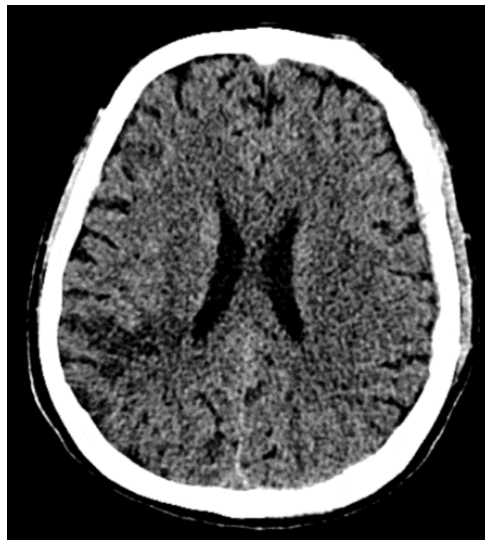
Axial brain non-contrast CT in the subsequent visit showed the hypodense lesion in right temporoparietal area
